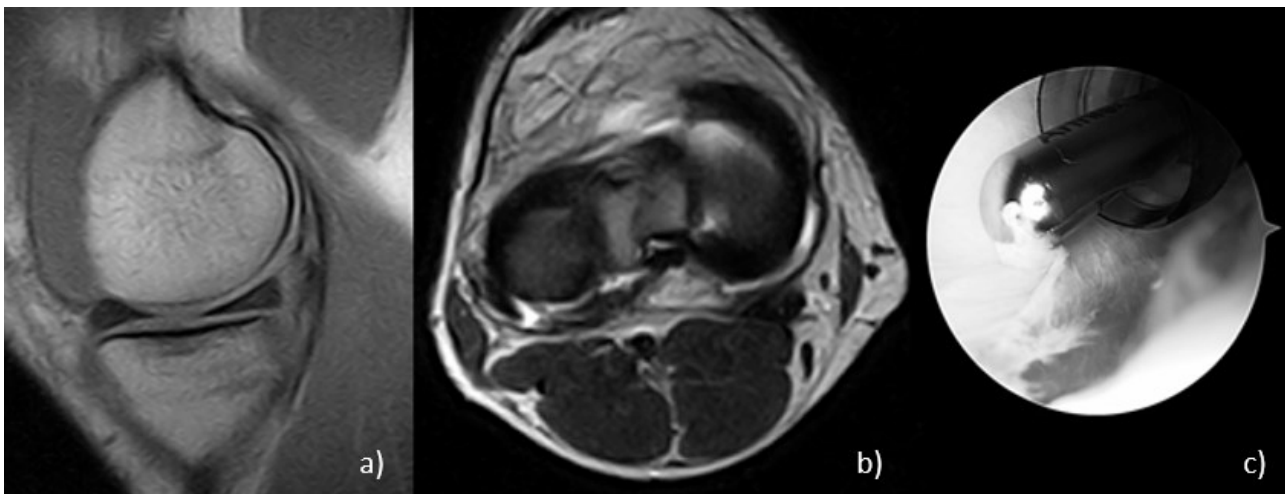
Sagittal PD (a) and axial T2 (b) weighted MRI images showing meniscocapsular separation of the posterior horn of the medial meniscus. Arthroscopic findings (c).
